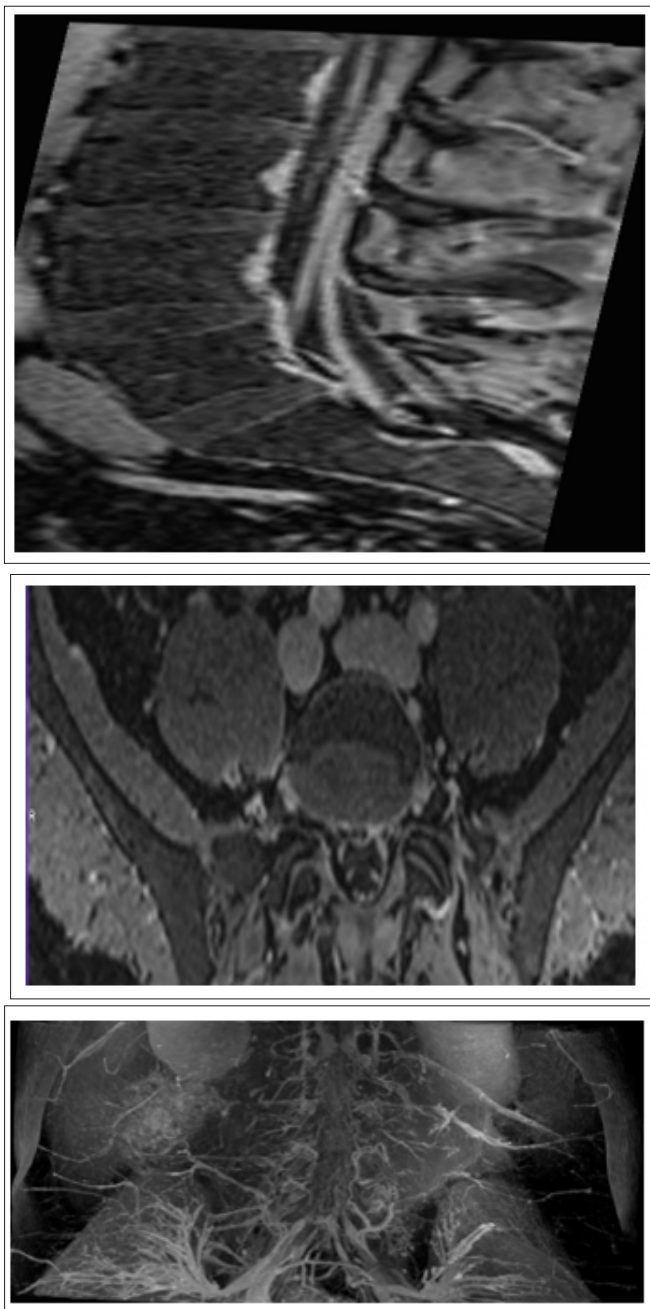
Magnetic Resonance Imaging on day 6, Abnormal Enhancement of Lumbosacral Nerve Roots, in Sagittal and Axial Projections after Gadolinium Contrast, 3D
